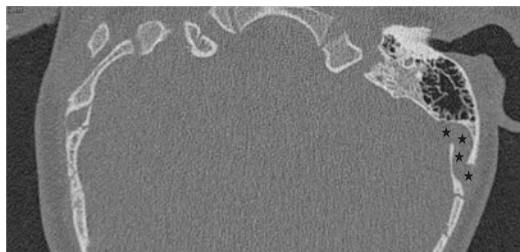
Temporal CT showing a huge emissary vein (black stars) at the craniotomy area
